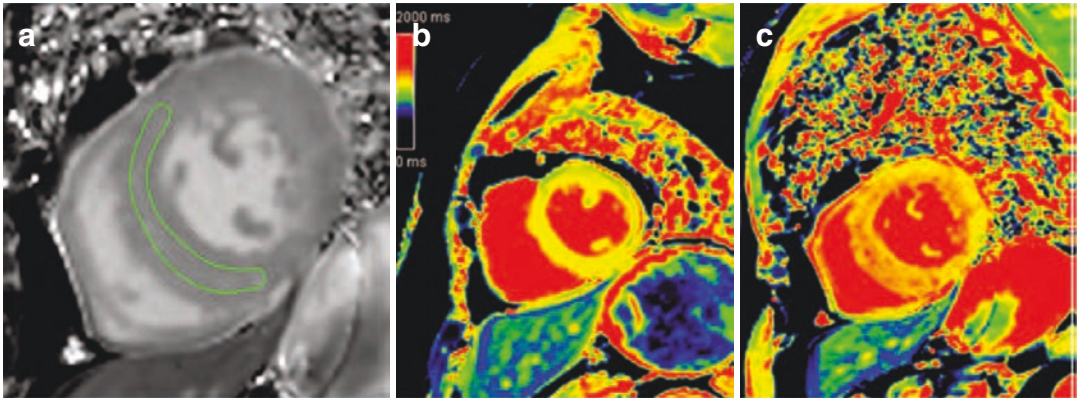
Representative native and T1 cardiac magnetic resonance imaging (cMRI) of diffuse myocardial fibrosis. (a) Diffuse myocardial fibrosis on the short-axis view of the cMRI image, with the circumference of the antero-septal myocardial area (region of interest). (b) cMRI T1 map
